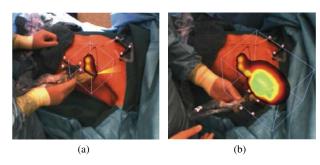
Visualization during the Freehand SPECT acquisition. AR is used to guide the users with respect to the scan coverage. Color augmented over the video shows the amount of information collected on the region (green/yellow = sufficient information, red/black = insufficient information)
